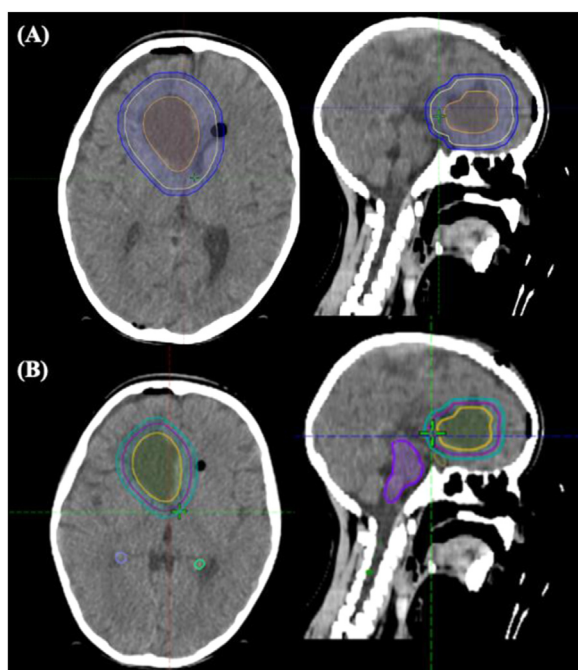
(A) Computed tomography and magnetic resonance fused images showing a radiation plan of 5400 cGy in 30 fractions to the resection cavity, with a cone down to a total dose of 5940 cGy in 33 fractions. The GTV is shown in gold, the CTV (GTV + 10 mm) in yellow, and the PTV (CTV + 3 mm) in blue. (B) Boost plan with the GTV in yellow, CTV (GTV + 5 mm) in purple, and PTV (CTV + 3 mm) in teal. *Abbreviations:* CTV = clinical tumor volume; GTV = gross tumor volume; PTV = planning target volume.
